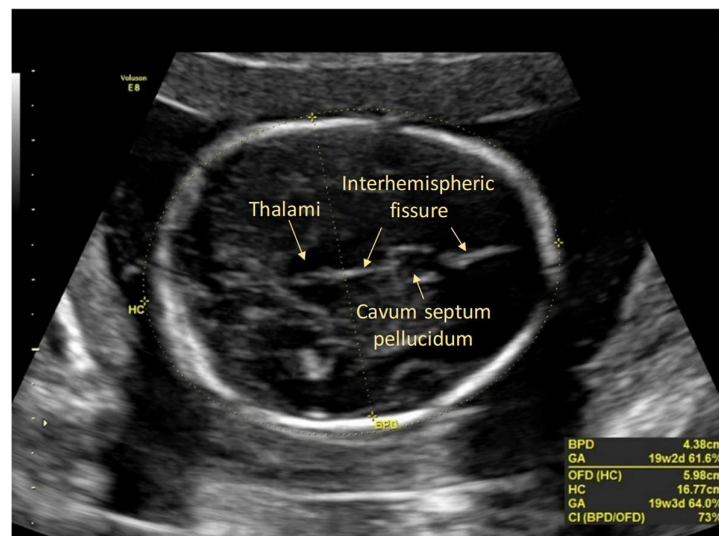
Fetal head imaged with contemporary ultrasound equipment at the measurement plane for biparietal diameter and head circumference. Note electronic 'on-screen' callipers and measurements displayed (bottom right corner) with equivalent gestational age and centiles for known gestational age. Image produced by D Paoletti.
